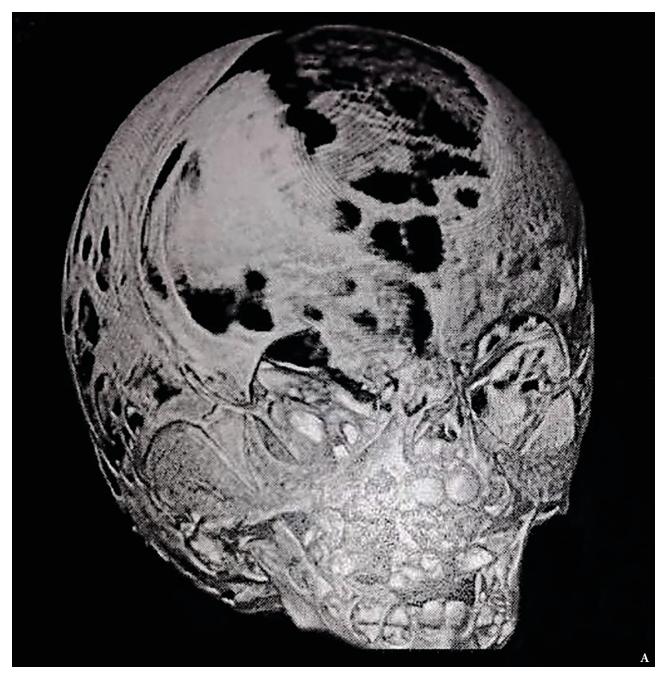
(A) Three-dimensional (3D) reconstruction CT scan of the skull evidence bilateral synostosis of the coronal suture, increase of the posterior digital marks. Noted the increase of the space of metopic suture. (Fig 2 continued on next page.)
